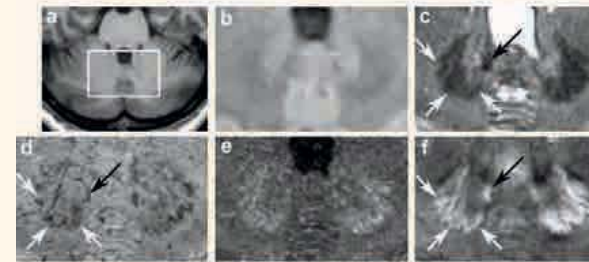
MRI of the cerebellar nuclei at 3T. T1-weighted image, FLAIR image, T2-weighted image, susceptibility weighted image, effective transverse relaxation ($R2^*$) map, and quantitative susceptibility map are shown from (a) to (f), respectively. The white box in (a) marks the region of the enlarged sections shown in (b-f). The white and black arrows indicate the dentate nucleus and the emboliform nucleus, respectively.
